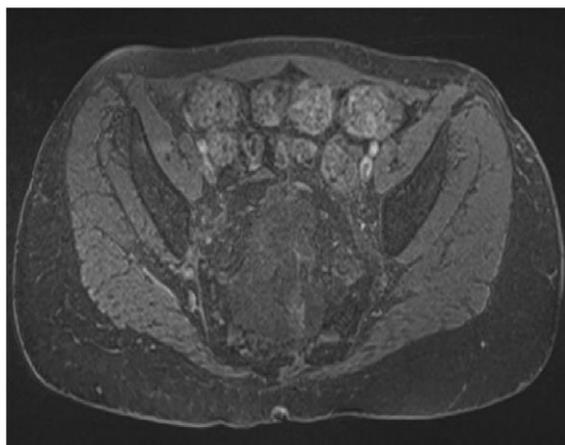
Post contrast axial MR image shows heterogeneous enhancement of the mass
